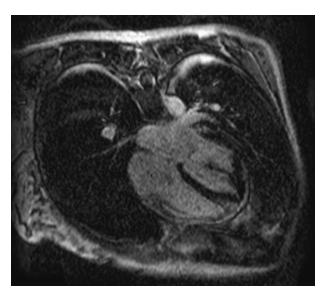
Patient's Cardiac MRI. Cardiac MRI showing the delayed enhancement in the myocardial region.
